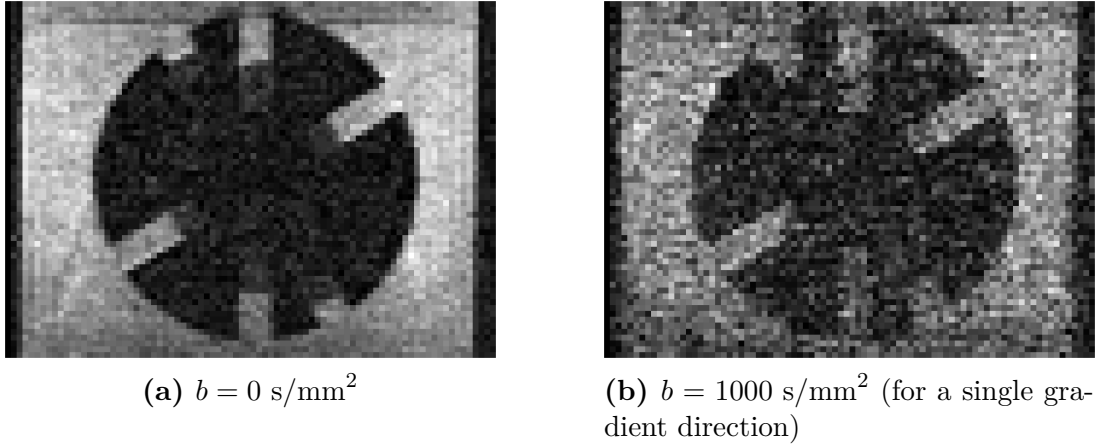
Diffusion MRI acquisition in the mid-coronal image plane.
